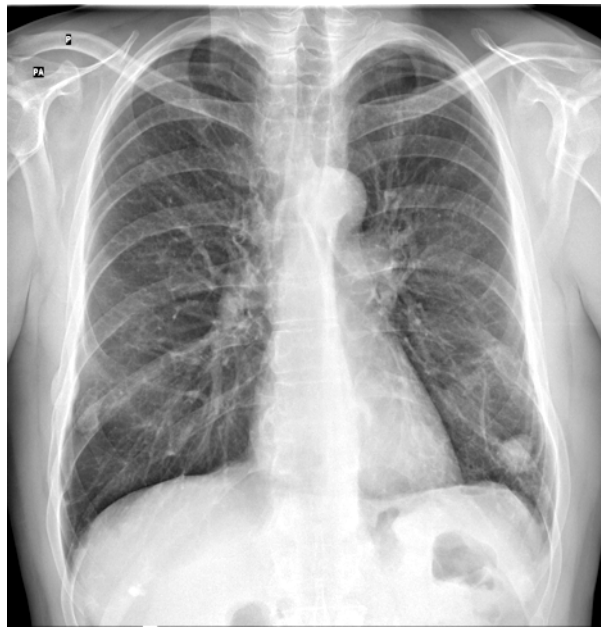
Chest radiograph — 25 × 23 mm focal lesion in the lower, left lobe
